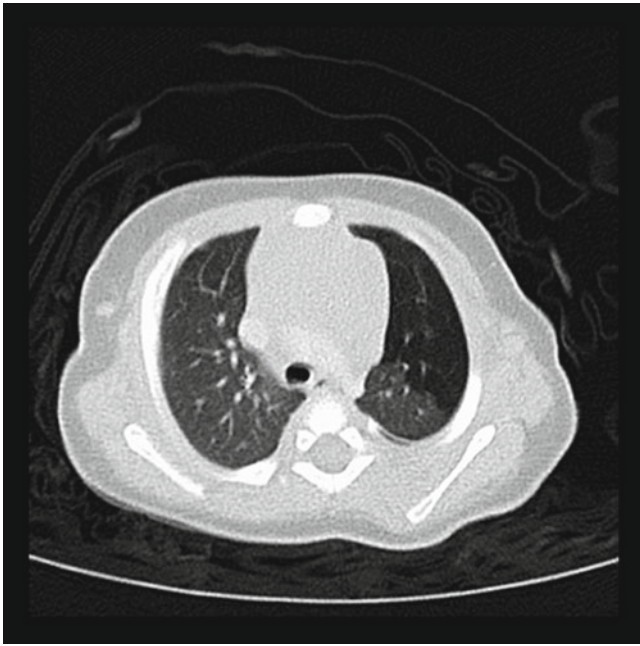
Bilateral congenital cystic disease is identified in this chest CT. This child underwent right upper lobectomy at 3 months of age for the larger, more significant disease. The left-sided disease is much less severe with cyst size of less than 1 cm. Surveillance CT is being performed on a 4–6-month basis to follow the lesion with regard to growth or other abnormal developments
